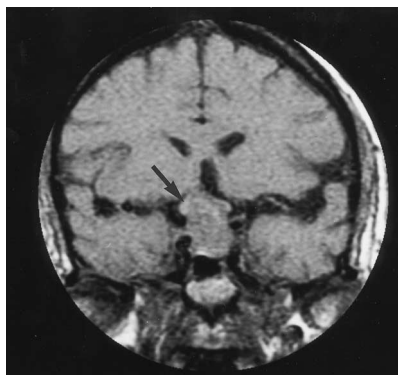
Coronal T1-weighted magnetic resonance image showing a pituitary mass of mixed signal intensity displacing and distorting the optic chiasm (arrow).
